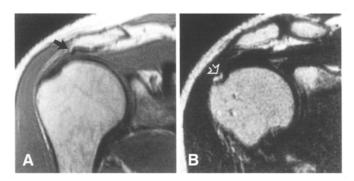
Partial tear of the supraspinatus tendon, caused by an impinging spur of the anterior acromion in a 43-year-old man. A Coronal MR image (SE 1800/15) shows a prominent spur of the lateral aspect of the anterior acromion (*arrow*). B Coronal MR image (SE 1800/70) reveals a focus of high-intensity signal, representing fluid in the inferior aspect of the tendon (*arrow*). The signal does not extend to the subacromial bursa
